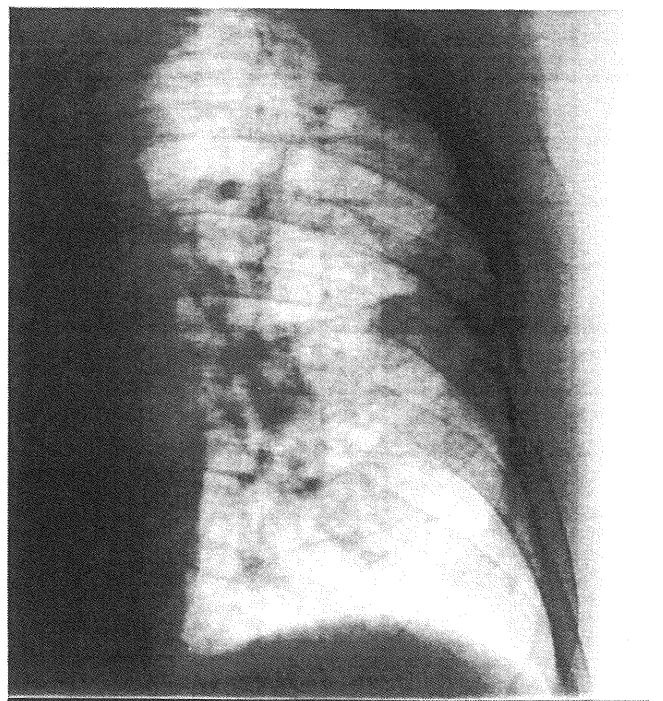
Fluoroscopic lung image. The X-ray parameters were 110 kVp, 80 mA, and 5 ms per shot. The monitoring dose was 0.117 mGy per pair of stereo shots.
